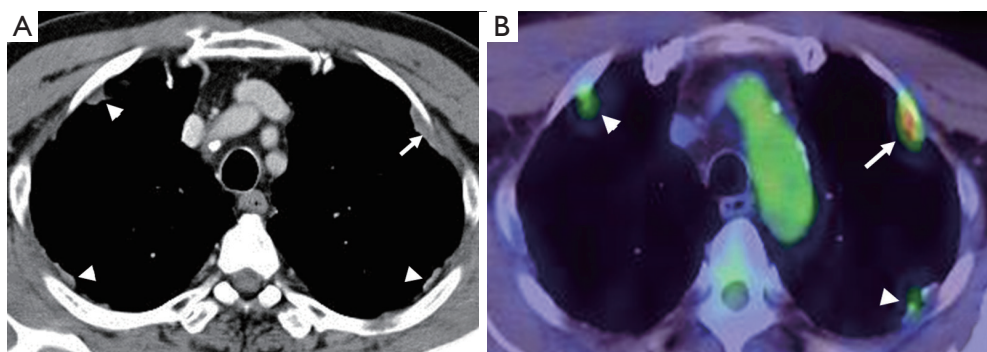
Chest computed tomography (CT) and positron emission tomography (PET) images of this case. (A) Enhanced chest CT scan revealed that the pleural tumor (white arrow) in the left thoracic cavity and pleural thickness and plaque (white arrow head) were diffusely located in the bilateral thoracic cavity; (B) ^{18}F -fluorodeoxyglucose-positron emission tomography (FDG-PET) showed that the maximum standardized uptake value (SUVmax) of this left sided pleural tumor was 4.84 (white arrow), and pleural thickness and plaque revealed a lower uptake (white arrow head).
